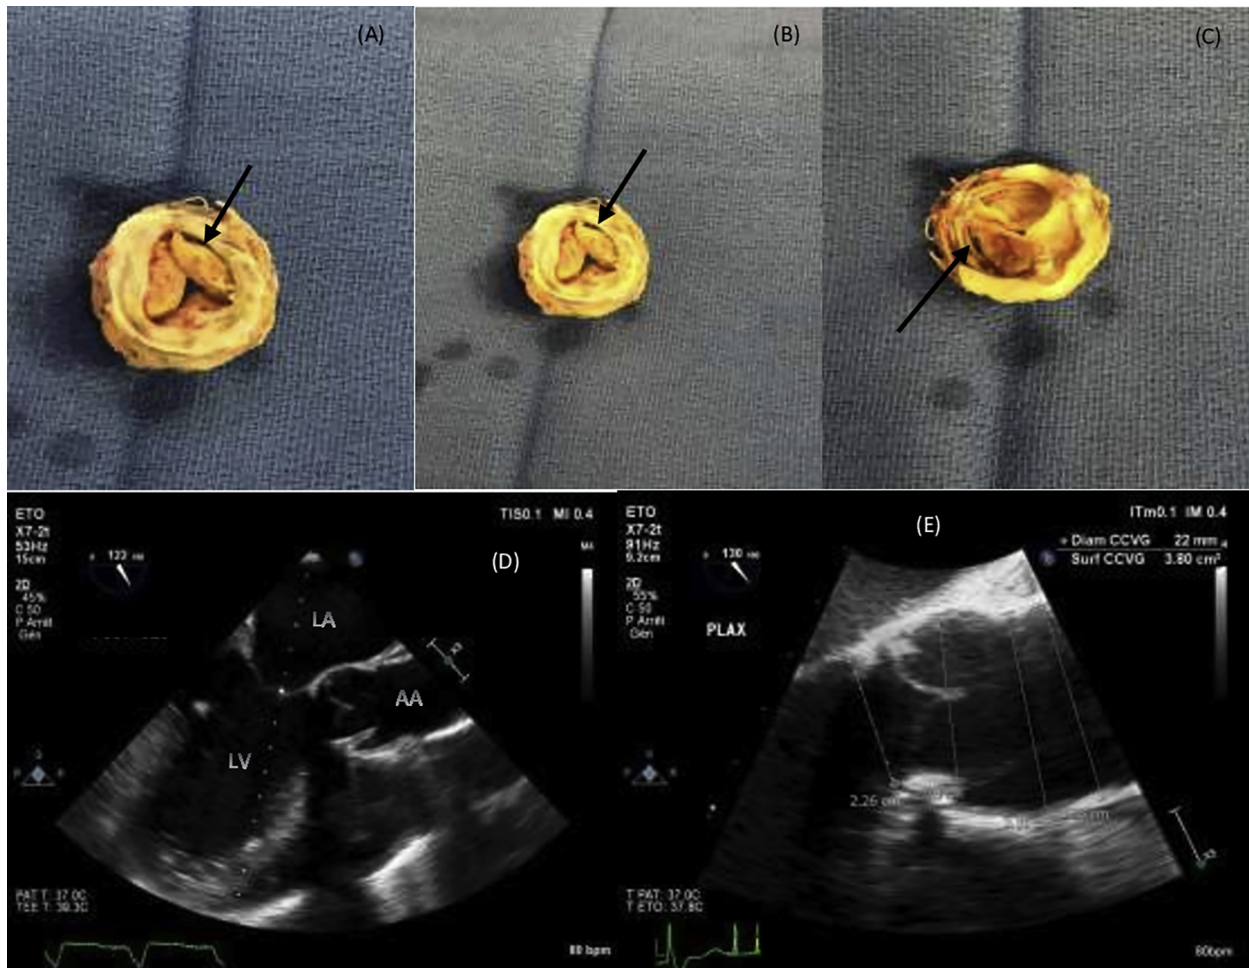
Explanted Carpentier-Edwards pericardial aortic bioprosthesis with pannus overgrowth and fibrosis in the sewing ring. We can also see thickened valve leaflets with a disinsertion of the base of the NC leaflet (*black arrow; A–C*). Postoperative transesophageal echocardiography showing AVR with a normal functioning bioprosthesis and the replacement of the NC sinus and the AA with a Dacron graft (D, E). LA, Left atrium; LV, left ventricle.
